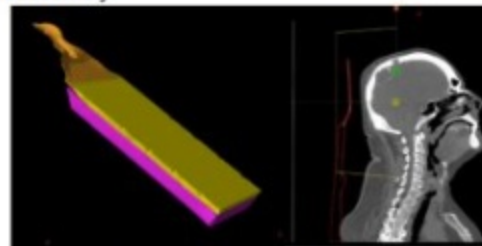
Qfix medium BoS insert on top of the proton couch base (magenta color) and Figure 3b shows the limited CT image set excluding the couch base.
